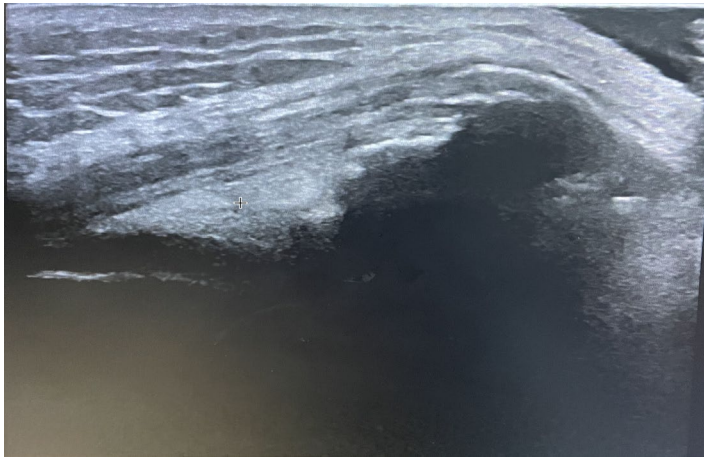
Ultrasound image of a patient with patellar enthesopathy
